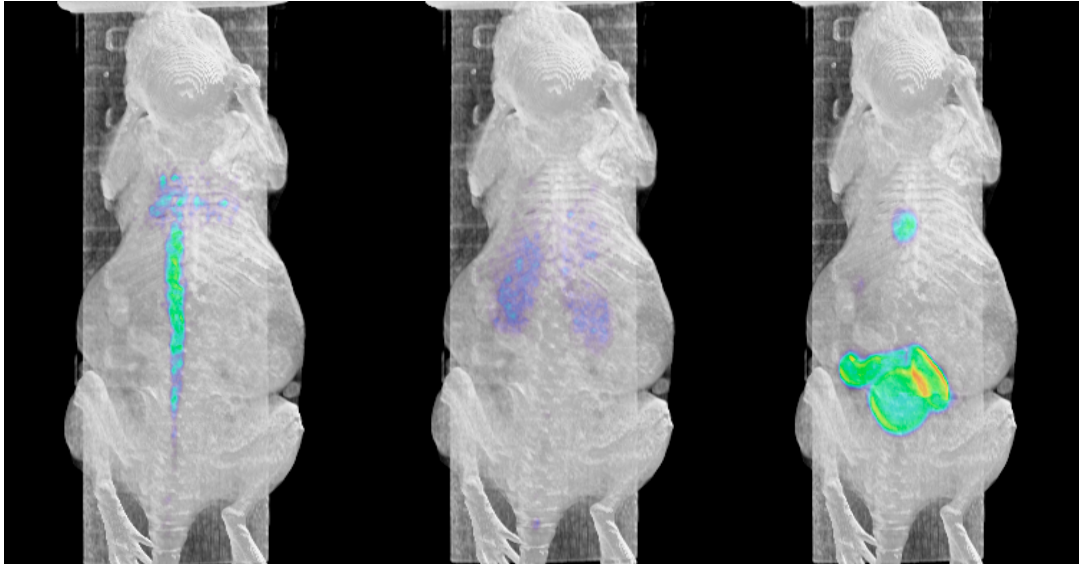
3D rendered PET/CT images of subcutaneous model showing the uptake of the tracer at different time frames (2.5 sec, 135 sec, 3450 sec)
